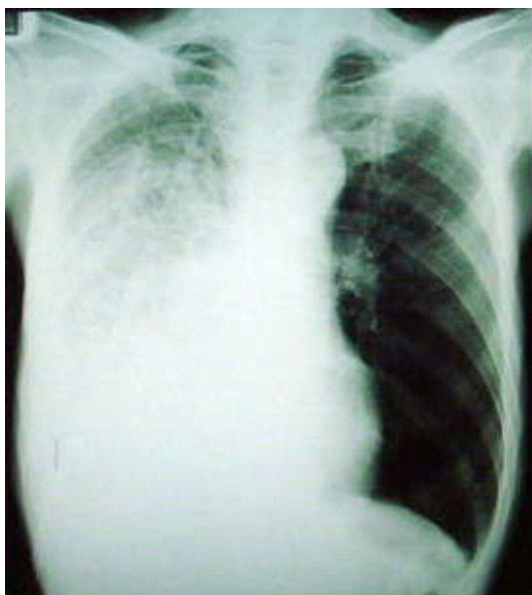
Posteroanterior chest radiograph 3 days after admission demonstrating increased opacification in the right lower zone
